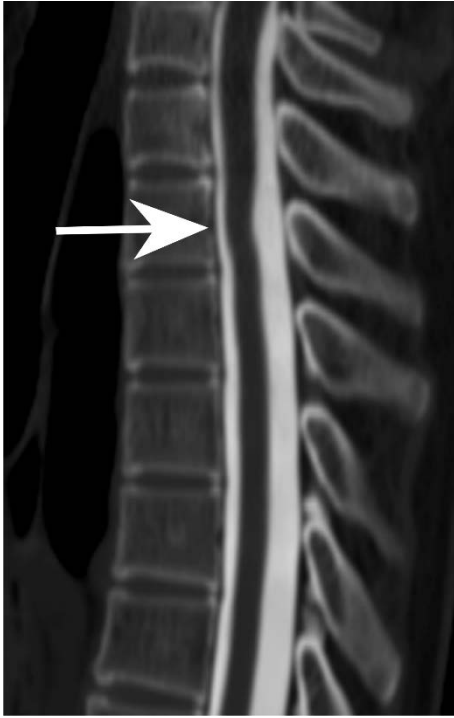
Cervical spine MR (A–D) and additional CT myelography (E–F) of a 38-year-old woman who presented with neck pain. The sagittal T2-weighted image (A) and the axial T2-weighted image (B) show an anteriorly displaced spinal cord at the T2/3 level with a hypointense elongated flow artifact in the extended dorsal space at the same level.
